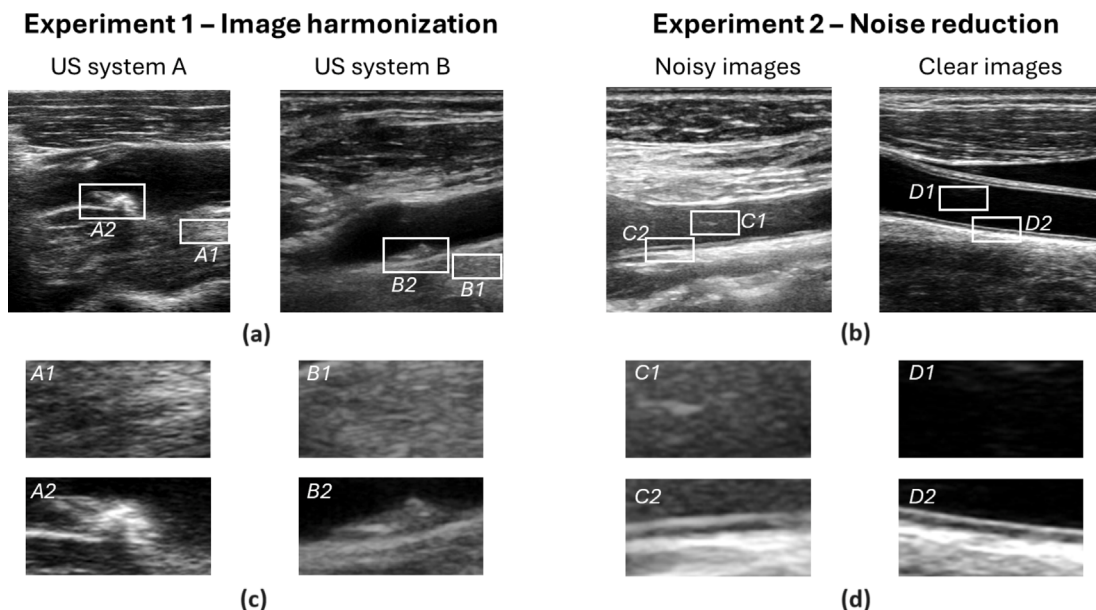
Examples of carotid ultrasound images used in the training of the domain adaptation task for the two experiments. (a) show examples for experiment 1 (image harmonization) that we define as domains A and B, respectively. (b) show examples for experiment 2 (noise reduction) that we define as domains C and D. In the lower panel, (c) and (d), regions of interests (ROIs) from the upper images are shown to zoom in on a homogeneous tissue segment (A1 and B1), a carotid plaques (A2 and B2), Lumen/blood (C1 and D1), and arterial walls (C2 and D2).
